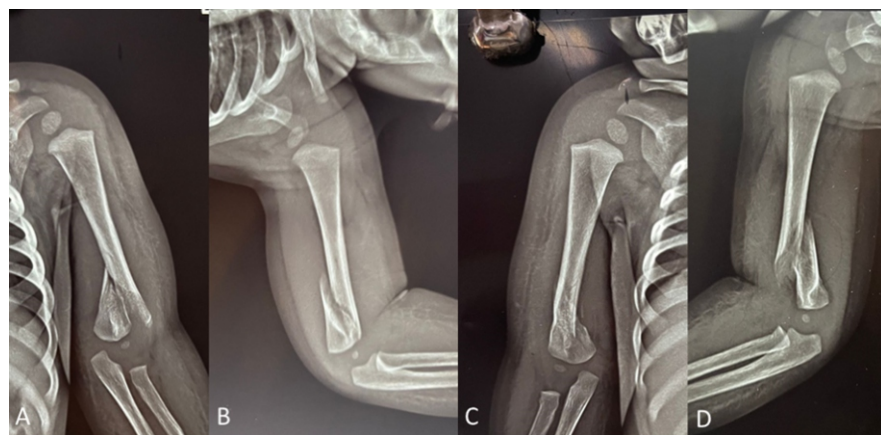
(a and b) Anteroposterior view and lateral view of left elbow radiograph showing 10 days old atypical spiral oblique supracondylar humerus fracture. (c and d) Anteroposterior view and lateral view of right elbow radiograph showing 10 days old atypical spiral oblique supracondylar humerus fracture.
